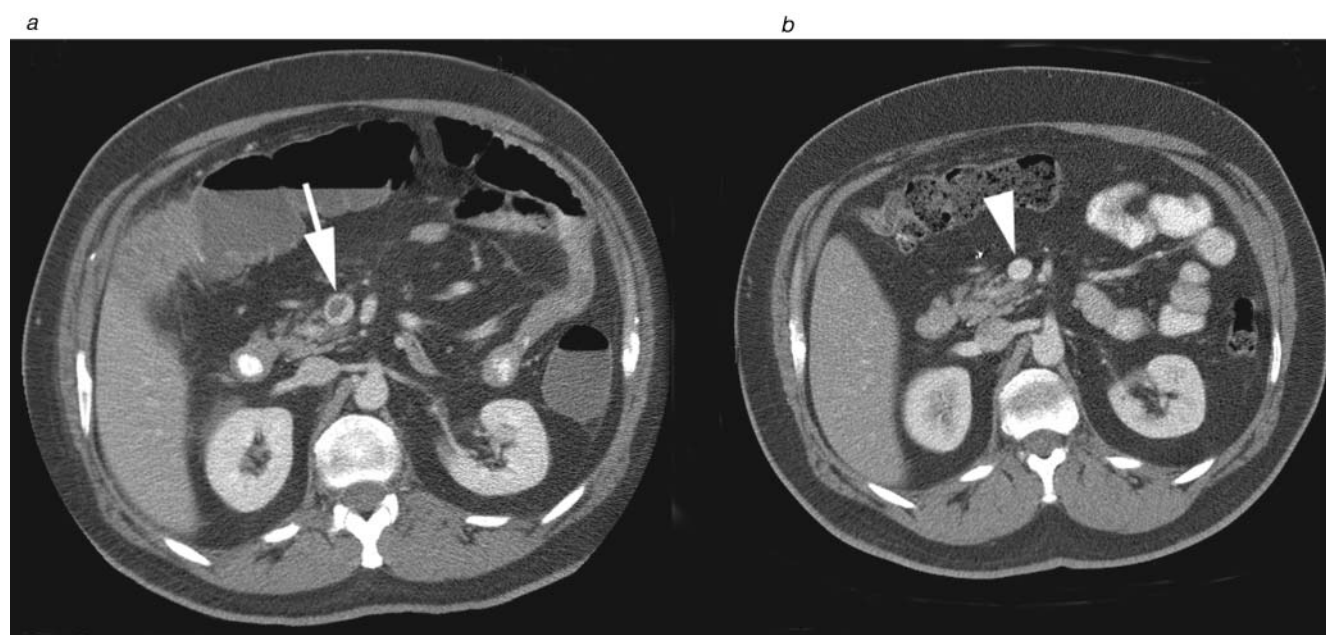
(a) Computed tomography (CT) scan shows partially occluding thrombus in the superior mesenteric vein (SMV) (arrow). (b) CT scan obtained 4 months later reveals complete resolution of thrombus (arrowhead).
